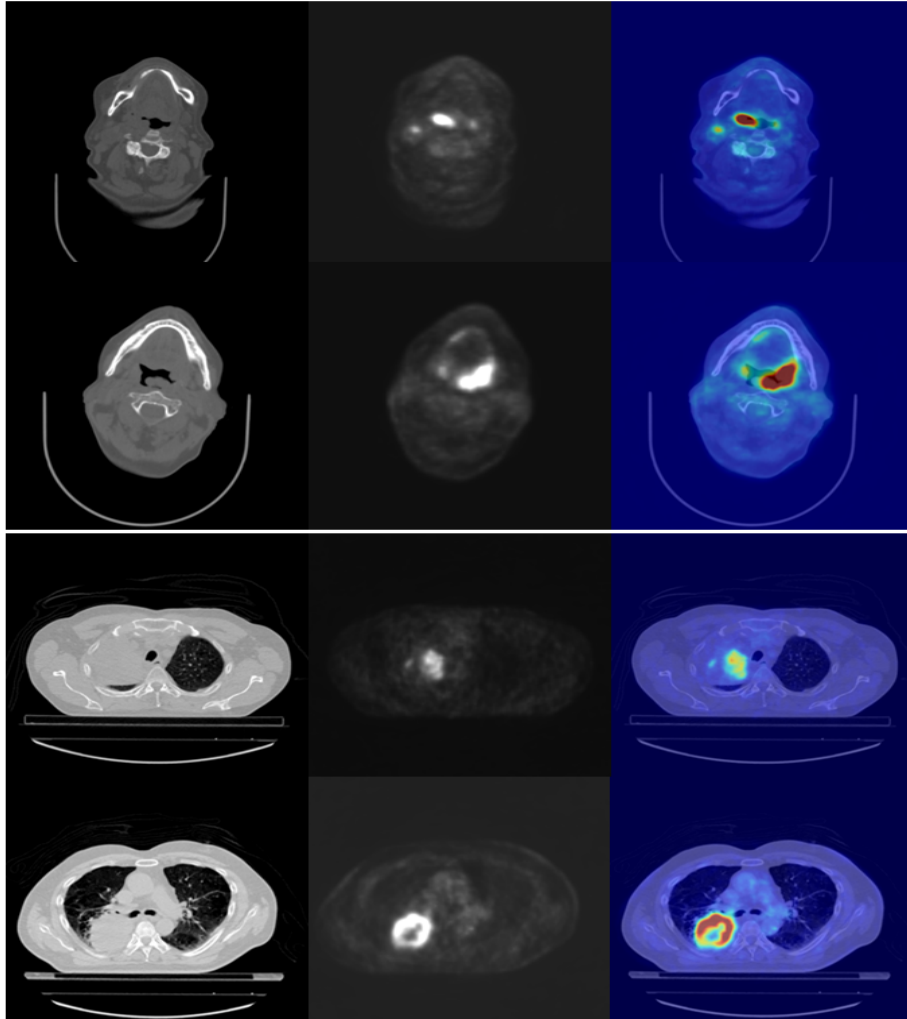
The important role of multimodal imaging in cancer screening. Examples of head-neck tumors (first two rows) and lung tumors (second two rows). The first column shows the anatomical CT images, the second column represents the molecular PET images, and the last column visualizes the fused images.
